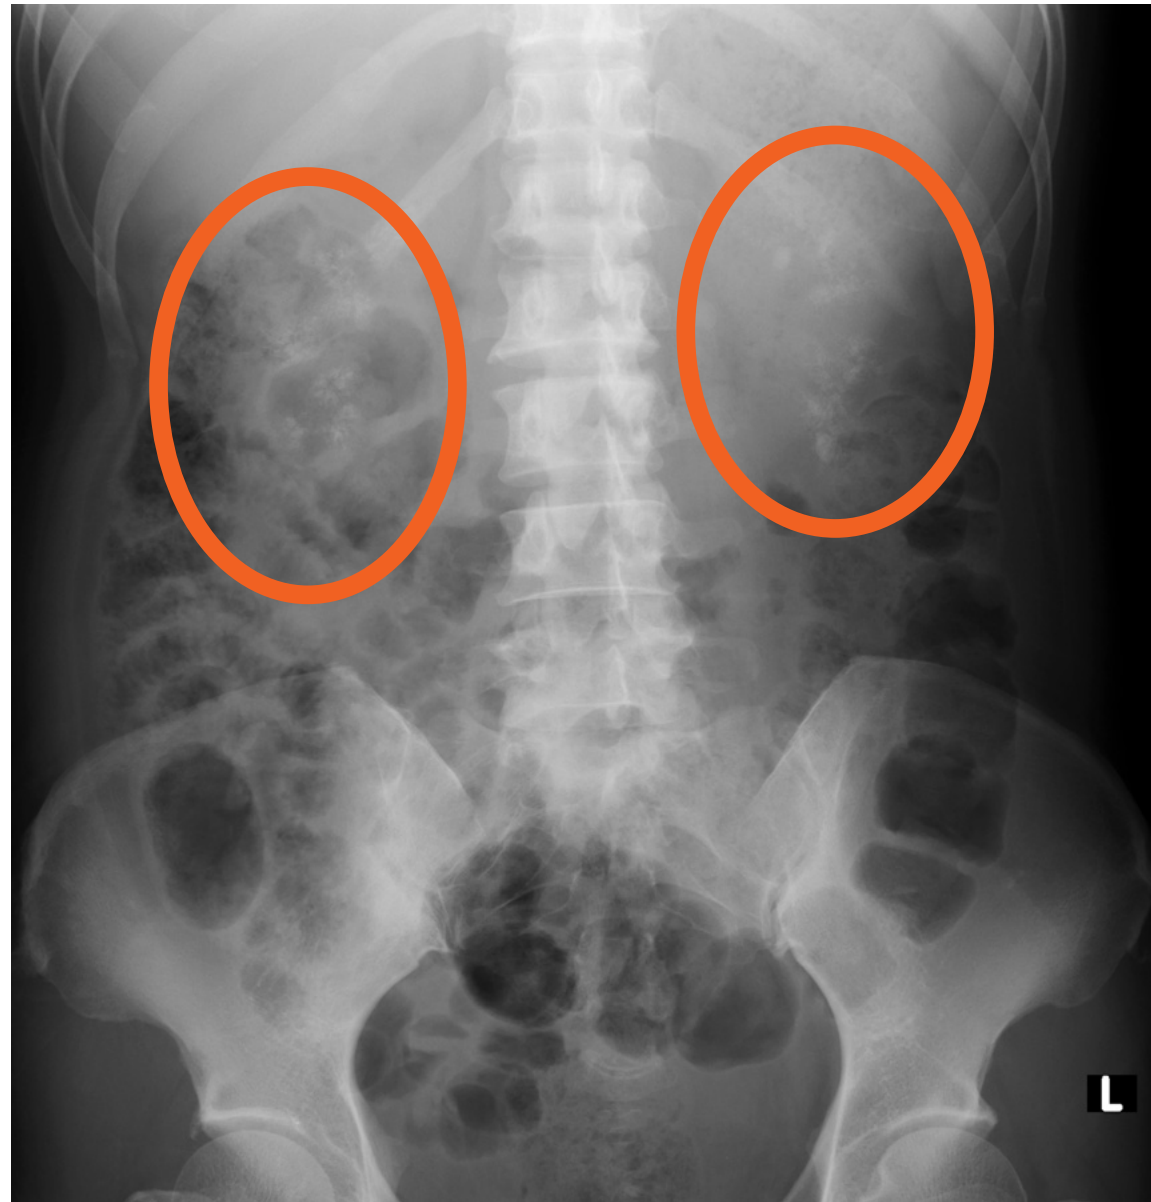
Radiograph showing bilateral cloud-like calcifications (circled) projected over the renal shadows.
